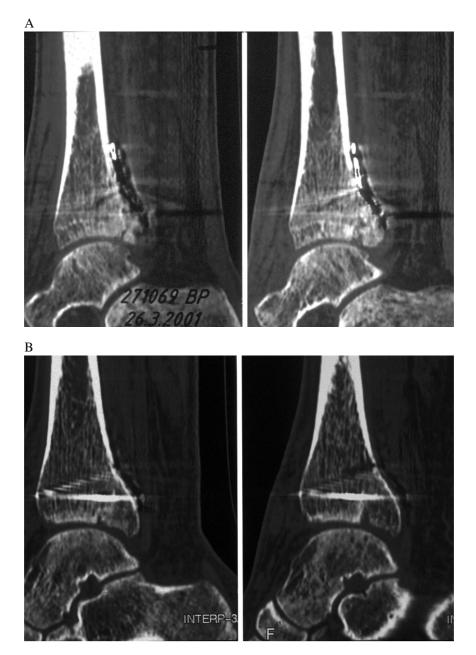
The sagittally reconstructed CT scans of the same patient show congruency in the lateral aspect of the tibiotalar joint (A). However, in the medial part of the plafond (B) and adjacent to the medial malleolus (C) posterior subluxation of the talar dome occurs (anterior "opening" of the joint).
